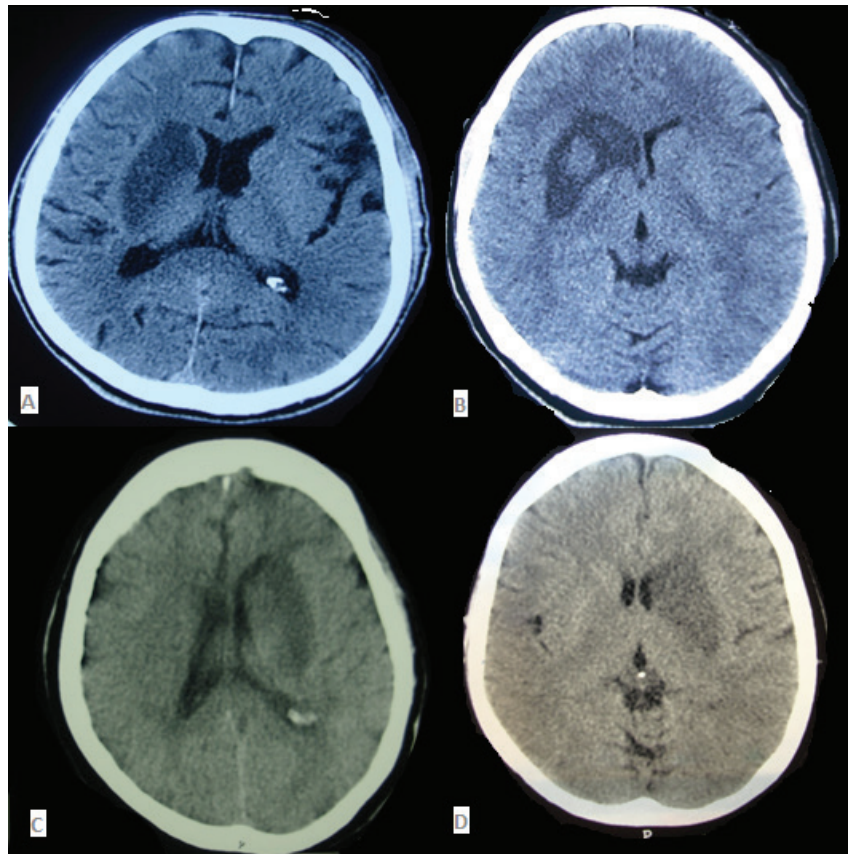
Non-contrast CT brain scans of our patients. (A) A 72-year-old retired male who was hypertensive, hyperlipidemic, and smoker. He presented with dense left-sided weakness and moderate facial weakness. He demonstrated normal language and speech but had left sensory inattention (patient 6). (B) An otherwise completely healthy 21-year-old single female presented with moderate left-sided weakness. She improved gradually over few weeks to a remarkable degree and returned to her pre-stroke activities. Her work-up did not uncover any cause behind this stroke (patient 11). (C) A 69-year-old female was referred to us in a coma state because of "a brain tumor and its massive surrounding edema." She developed progressive obtundation over few hours but a history of lateralized weakness was not clear. Upon recovery, she demonstrated severe expressive dysphasia (patient 1). (D) A 60-year-old woman with a history of severe mitral stenosis, atrial fibrillation, and pulmonary hypertension, presented with sudden dense right-sided weakness and slurred speech (patient 4). None of the aforementioned patients developed dystonia, involuntary movements, or Parkinsonism during a period of 3 months of follow-up. Note that the caudate is infarcted in all but patient 6 and that hemorrhagic transformation developed in patient 11.
